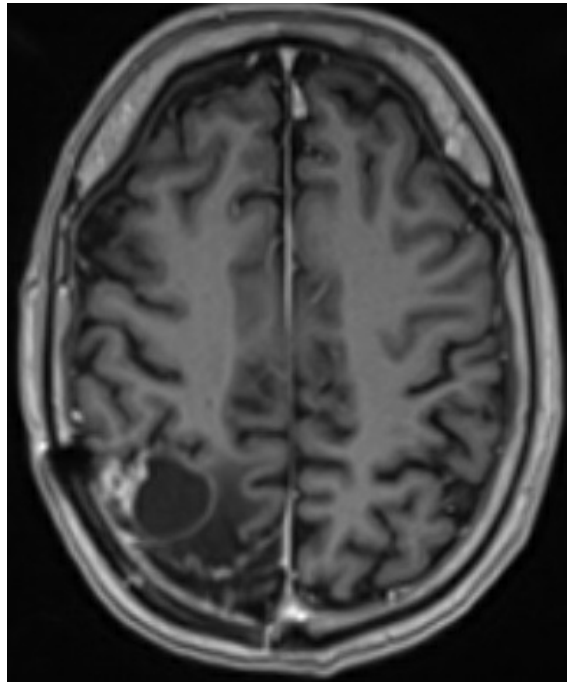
MRI showing cystic right parietal tumor recurrence with peripheral contrast enhancement.
